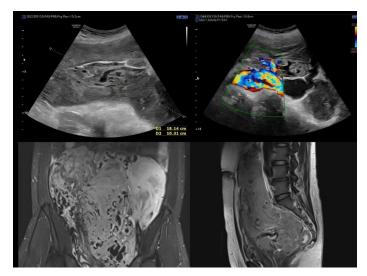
Transabdominal USG showed Large well defined lobulated heterogenous hypoechoic mass lesion with internal vascularity and MRI Abdomen and pelvis in sagittal T1 and coronal T2 fat saturation showed large lobulated heterogeneously T2 hyperintense lesion with multiple dilated vessels within noted in lower abdomen and pelvis.
